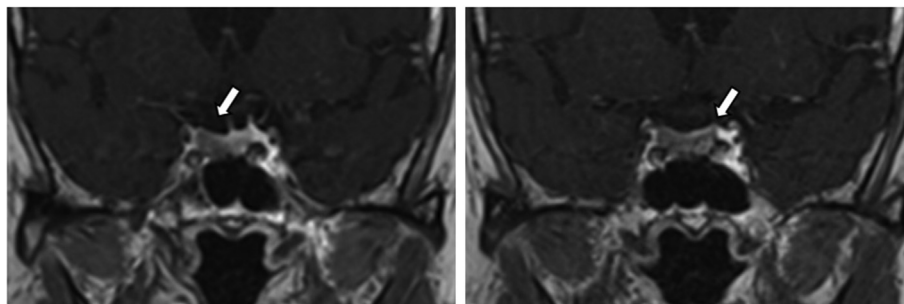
Magnetic resonance imaging of the pituitary showing two focal lesions in the right and left lateral wing of the pituitary.
